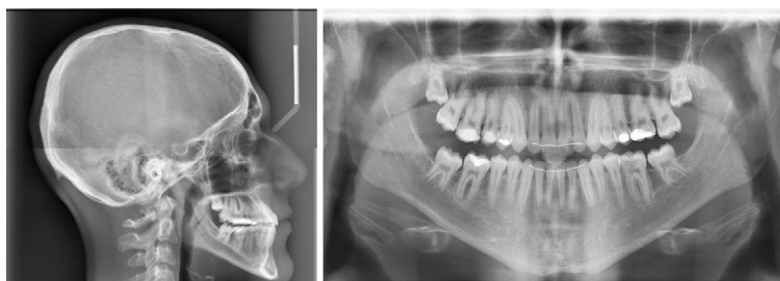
Cephalometric and panoramic radiographs of case 1 after orthodontic treatment.
